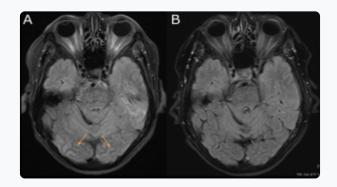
Cortical oedema and contrast extravasation in FLAIR hyperintensity (orange arrows, A). Regression of those features at day +7 (B).
